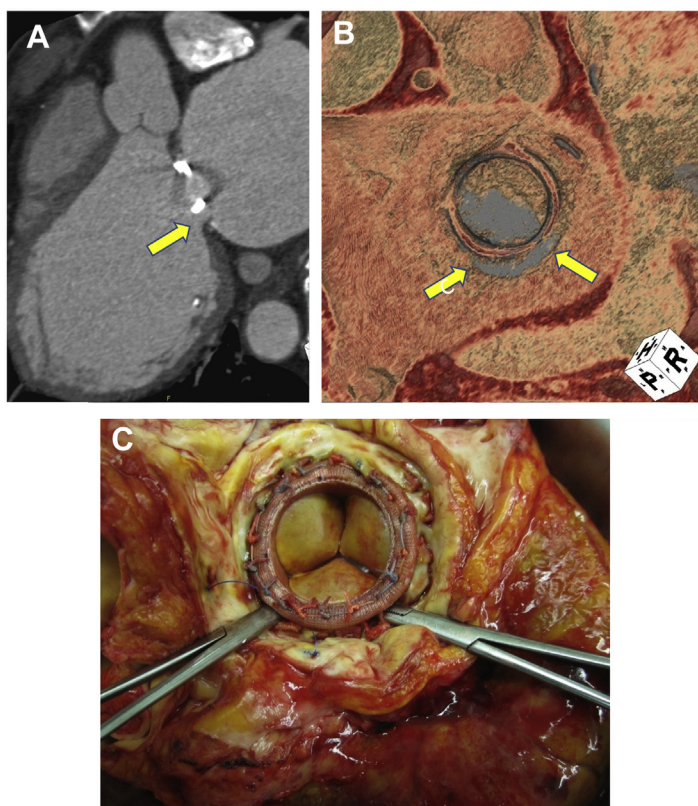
Large crescent-shaped dehiscence (yellow arrows) that involved posterior part of the mitral annulus on CT images (A, B). A single large PVL in surgical inspection was confirmed. Surgical instruments indicate the medial and lateral ends of the paravalvular dehiscence (C).
